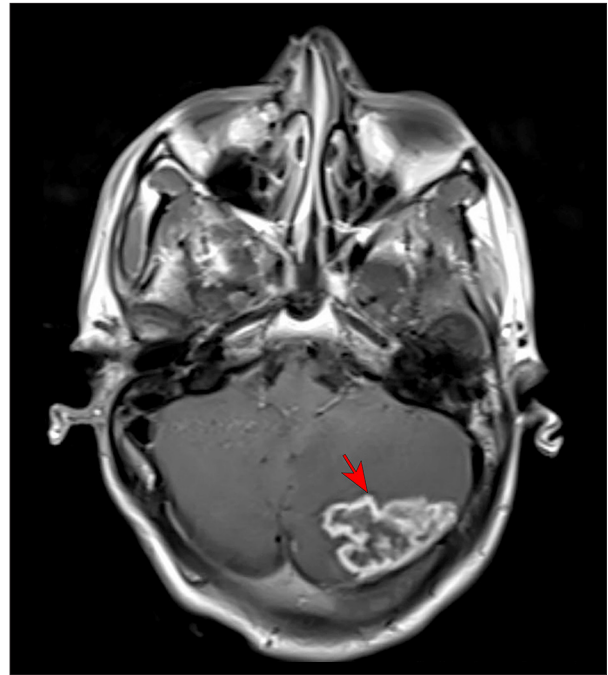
MRI head (red arrow: irregular intra-axial mass (3x4x2.7 cm) in the posterosuperior aspect of the left cerebellar hemisphere abutting the inferior surface of the left tentorial leaflet.
